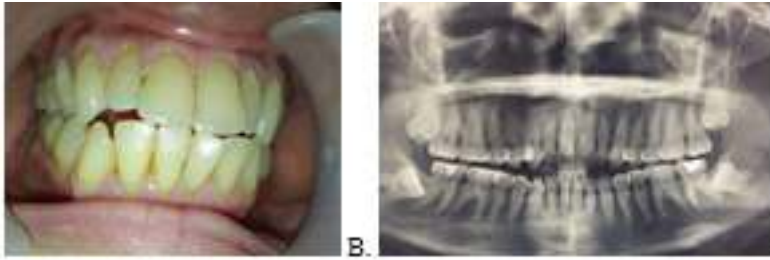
(A) Clinical before surgery. (B) Radiographic imaging
